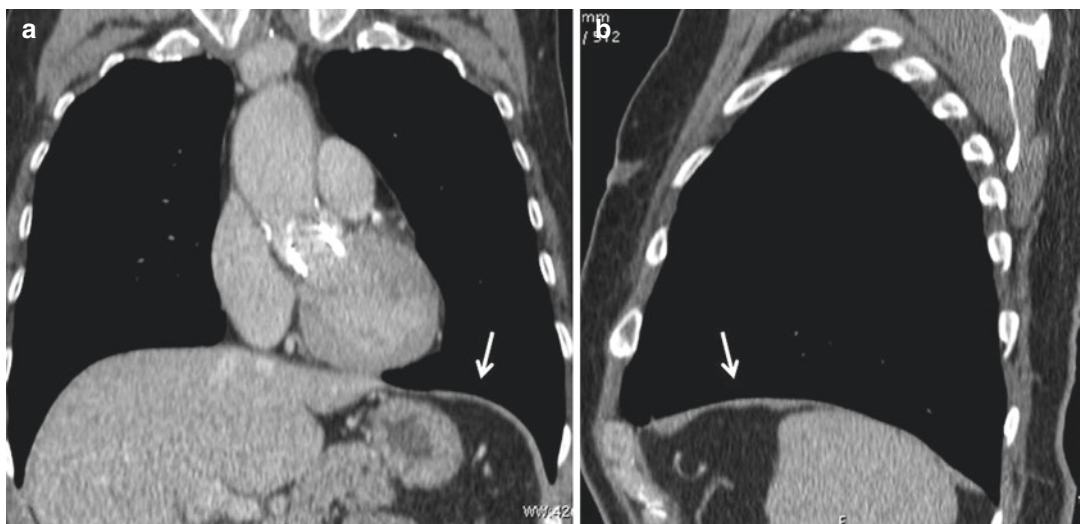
Normal CT anatomy. Coronal (a) and sagittal (b) MPR images contribute to the evaluation of the diaphragmatic profile (arrows). Note the poor visualization of the muscle in the portions next to the liver and the spleen
